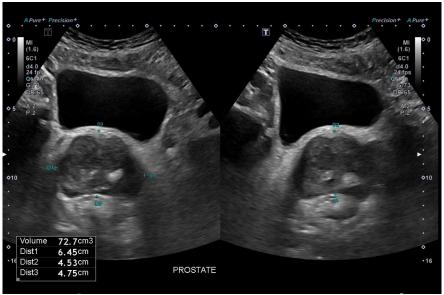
Post-treatment prostate ultrasound (September 2025)
